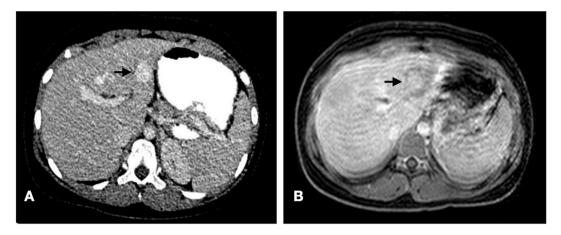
(A) Enhancing segment III liver lesion noted in CT scan (black arrow). (B) MRI liver dynamic post-gadolinium sequence revealed avid contrast uptake and persistent central enhancement in delayed images (black arrow). Motion artefacts were present in the delayed phase images as the child could not tolerate the scan much longer.
